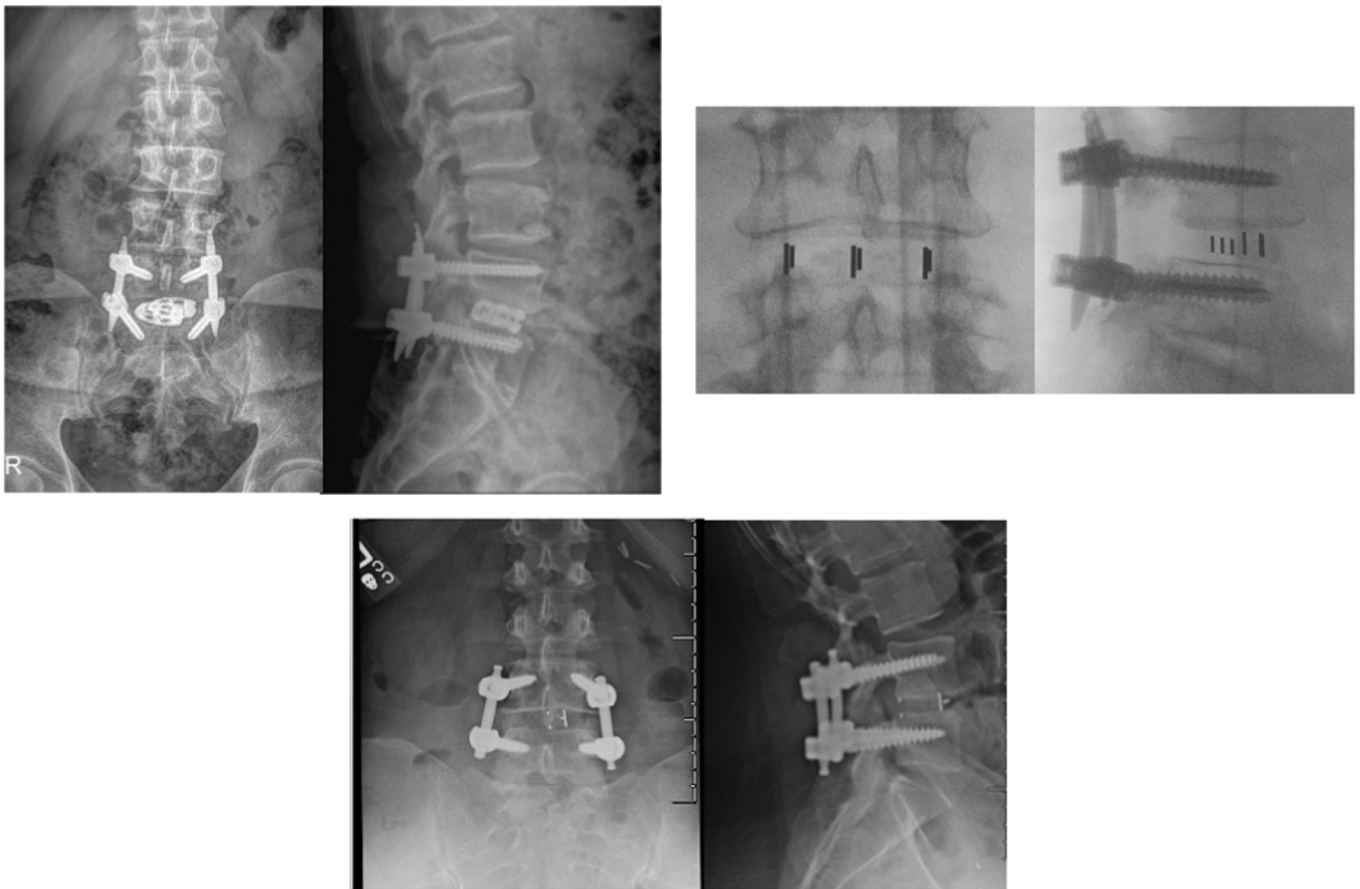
Clinical radiographs of the three strategies used A) two titanium small cages B) Large PEEK cage C) small PEEK cage.
